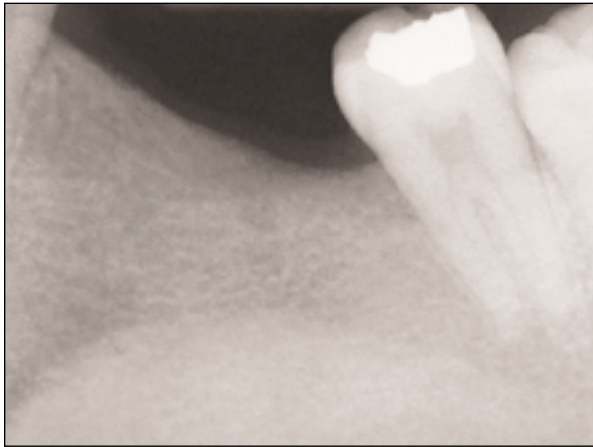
Pretreatment radiograph demonstrating no pre-existing bone pathology.
